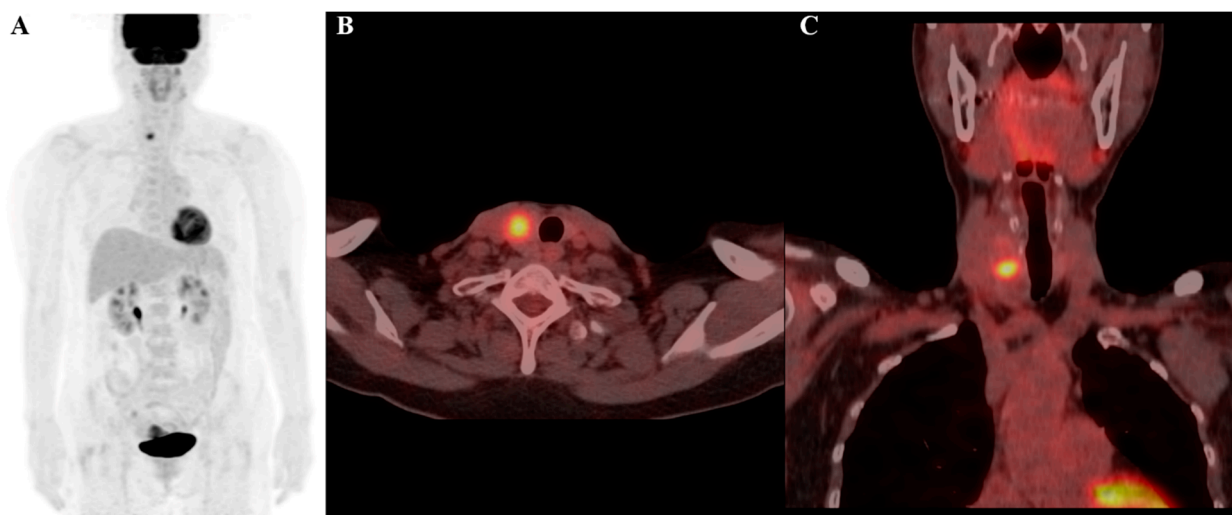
F-18 FDG PET/CT image of a 69-year-old female patient, highlighting a thyroid incidentaloma in the right lobe of the thyroid gland: (A) maximum intensity projection (MIP); (B) axial PET/CT image; and (C) coronal PET/CT image. The lesion demonstrates increased FDG uptake with a maximum standardized uptake value (SUVmax) of 9.2. Radiomic features include a log-sigma-2-0-mm-3D_glszm_SmallAreaEmphasis value of 0.553 (relatively low) and a wavelet-HLH_gldm_LargeDependenceLowGrayLevelEmphasis value of 33.814 (relatively high). Despite the high SUVmax, the final diagnosis confirmed the nodule to be benign.
